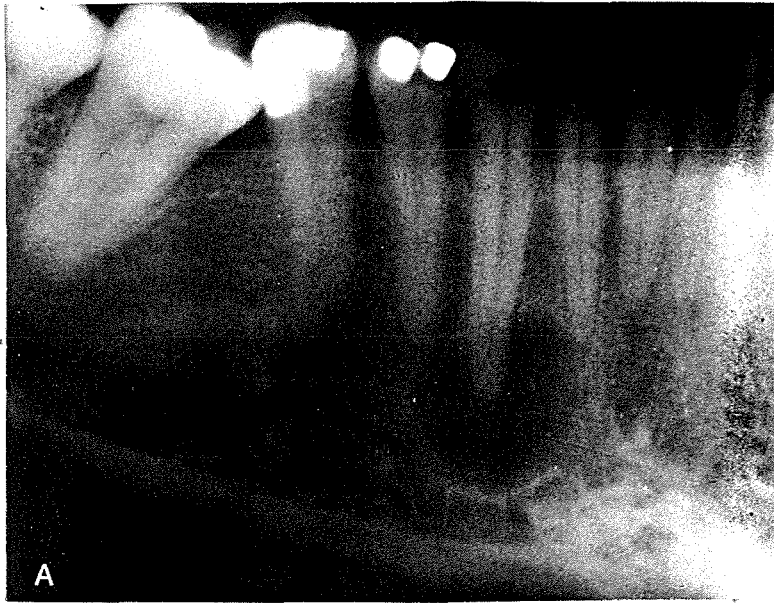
Cementifying fibroma appearing as a cyst like radiolucency resembling a periapical cyst
